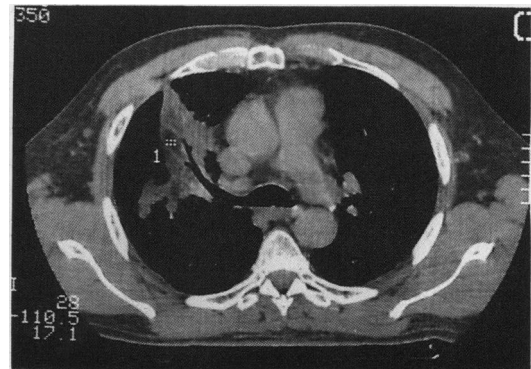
(a) Computed tomogram showing fatty density (-110 HU) in the right upper lobe lesion, which is specific for lipoid pneumonia. (b) Cardiac gated magnetic resonance (time repetition 717, time echo 34 ms) in the axial plane. High signal intensity mixed with intermediate signal intensity is seen in the right upper lobe.
